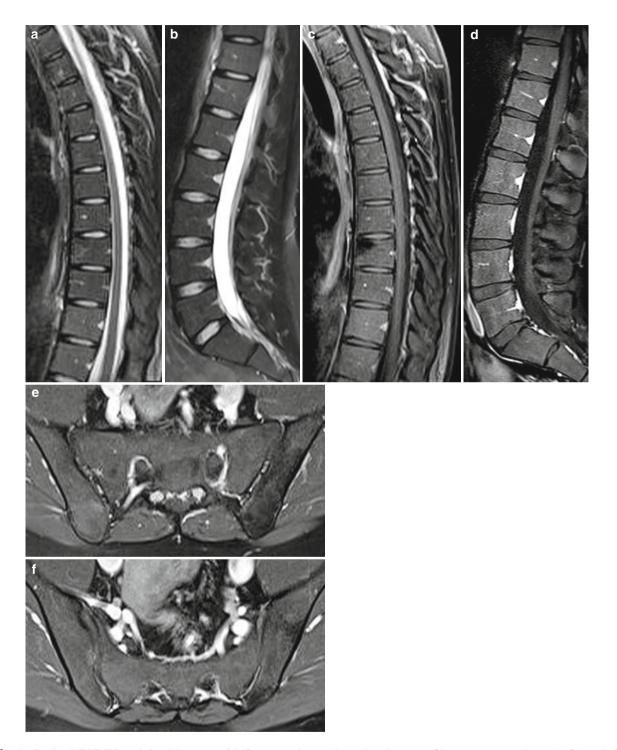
Sagittal TSE T2-weighted images with fat saturation $(\mathbf{a}-\mathbf{b})$, sagittal SE T1-weighted images with fat saturation following the administration of contrast medium $(\mathbf{c}-\mathbf{d})$, and axial SE T1-weighted images with fat saturation following the administration of contrast medium $(\mathbf{e}-\mathbf{f})$. These images
